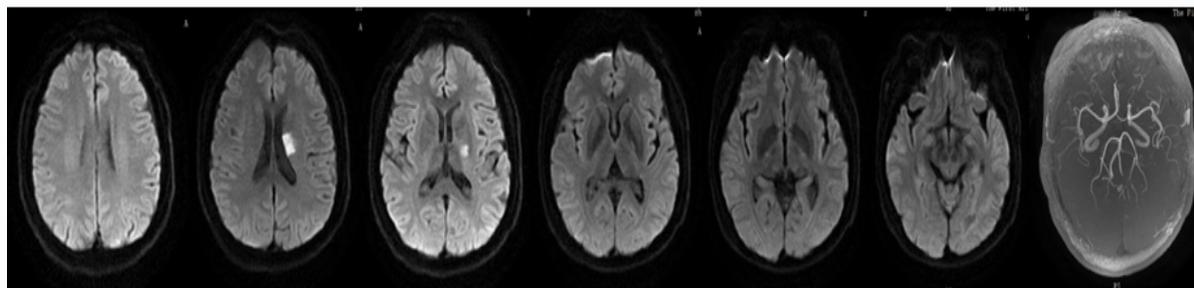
The lesions appearance in axial sections in the lenticulostriate artery region on the DWI sequence.
